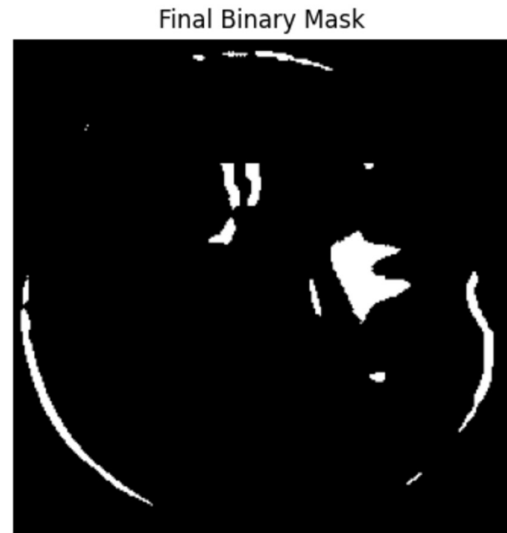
FLAIR MRI Image with Binary mark and of MS Lesions
